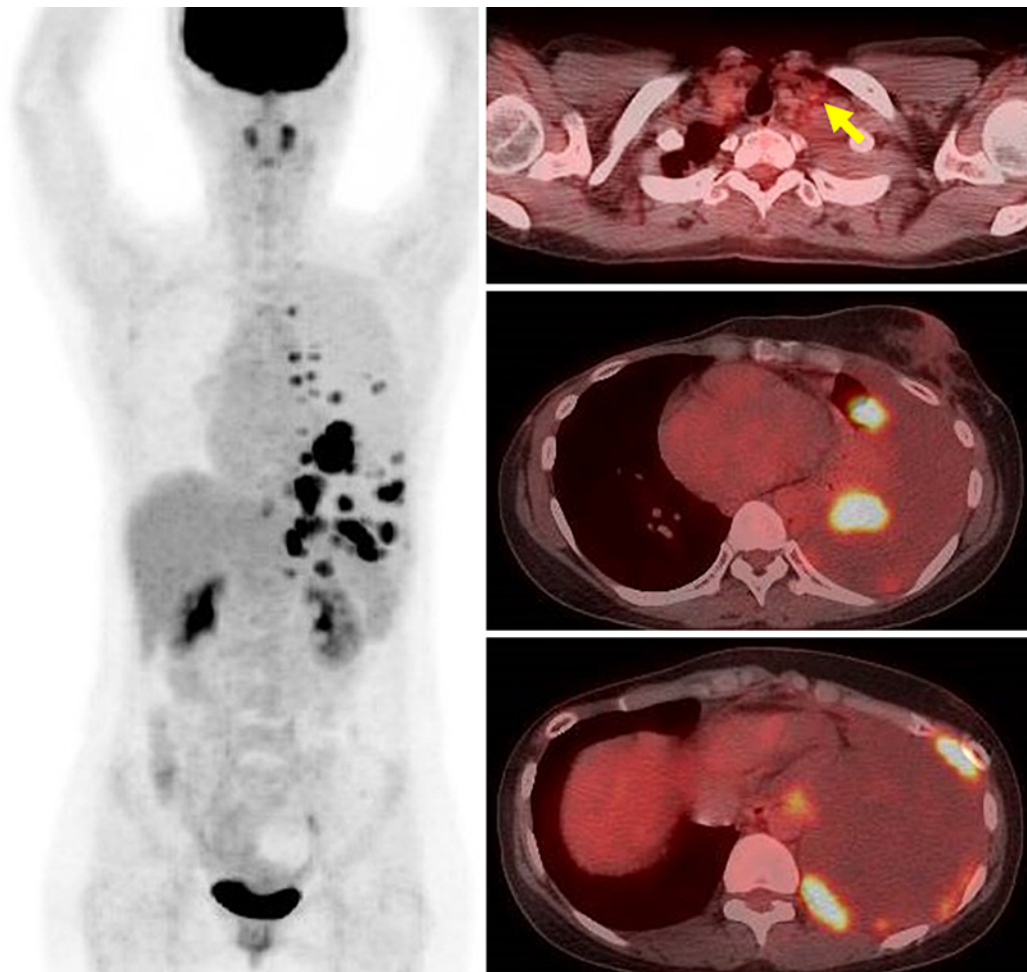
Positron emission tomography/computed tomography image showing multiple lung metastases, pleural dissemination, pleural effusion, and supraclavicular node metastasis. The arrow indicates the supraclavicular node metastasis.
